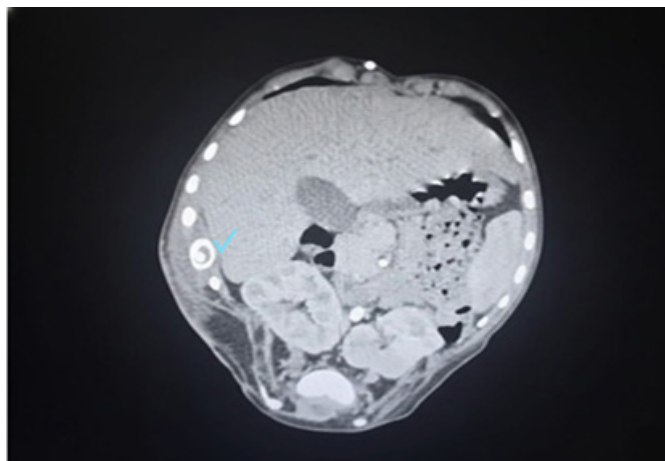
Computed tomography (CT) image demonstrating lytic destruction and enlargement of the distal segment of the right 10th rib. The blue arrow highlights the VP shunt catheter positioned within the costal bone.
